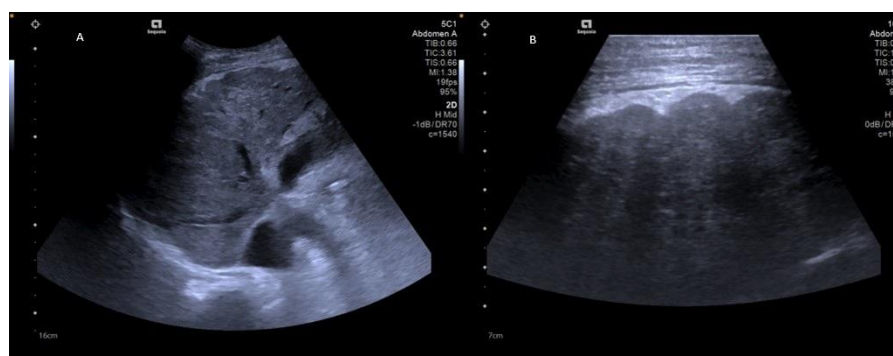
Ultrasound images of a liver from a female participant in her 50's with HCV
